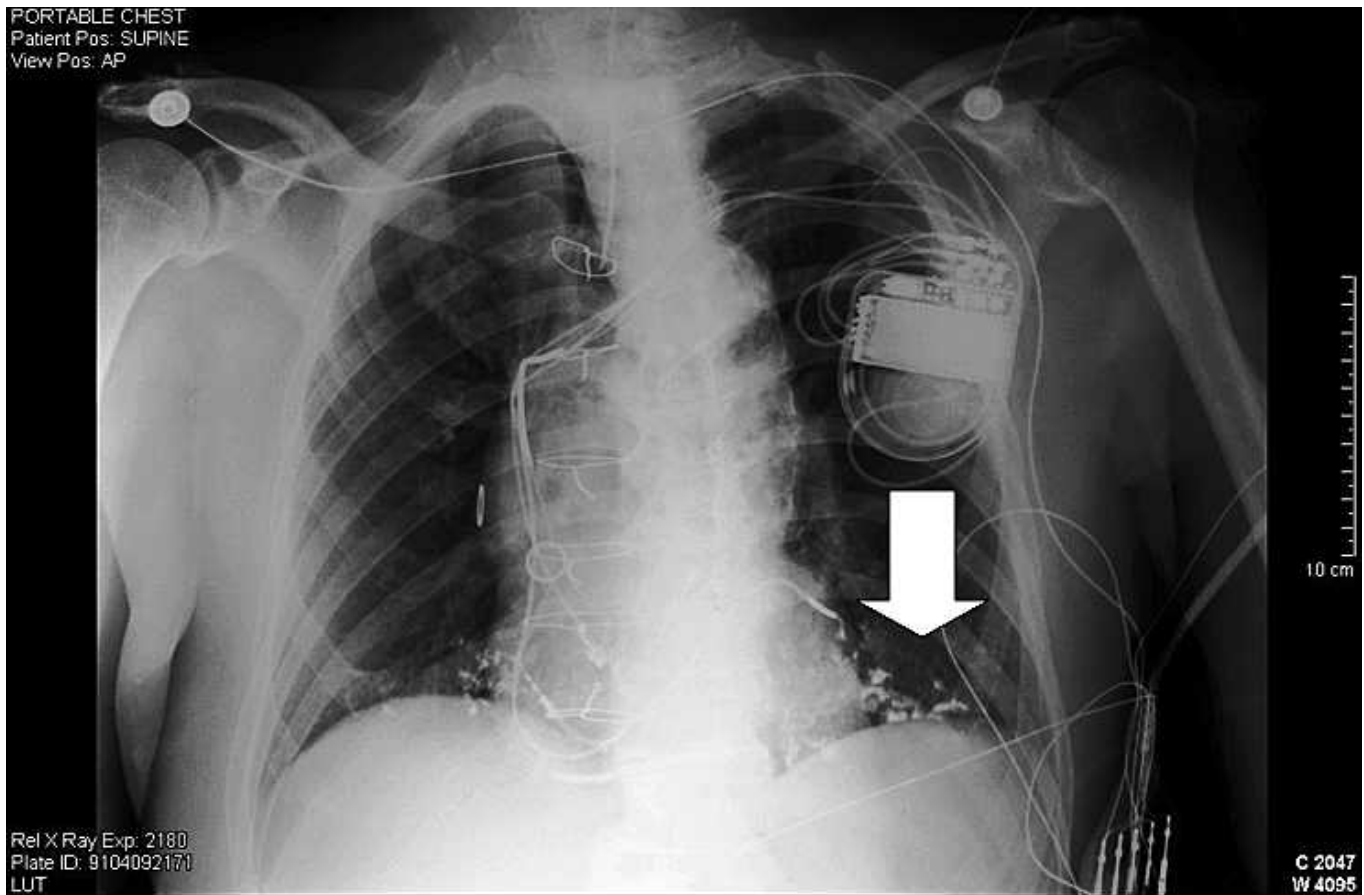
Chest radiograph showed retained barium in bilateral lower lobes of lungs (arrow) with atelectatic/pneumonitic changes and osteophytes in distal right clavicle and both shoulders.
